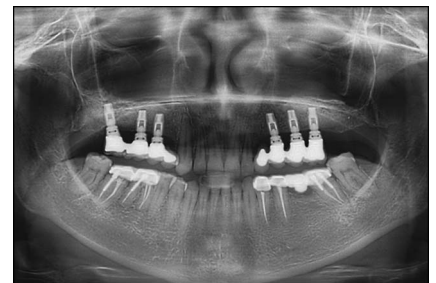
Panoramic radiograph of the 6 implants immediately after placement.
